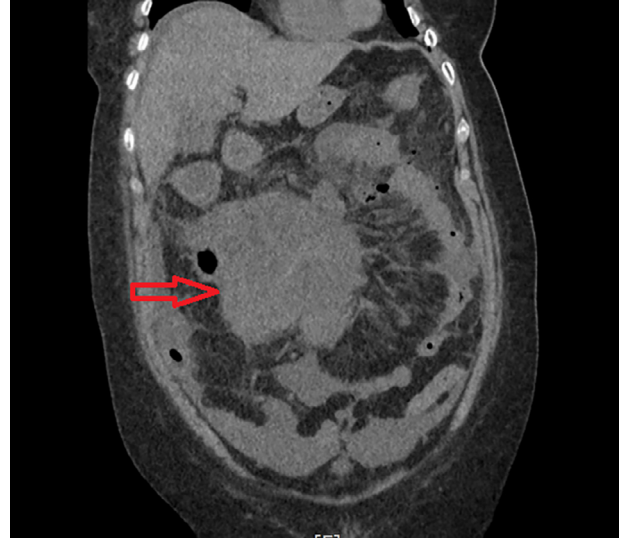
CT scan, coronal section, showed a large heterogeneous necrotic cystic/solid mass in the right small bowel mesentery measuring 9.5 × 15 cm (red arrow).
